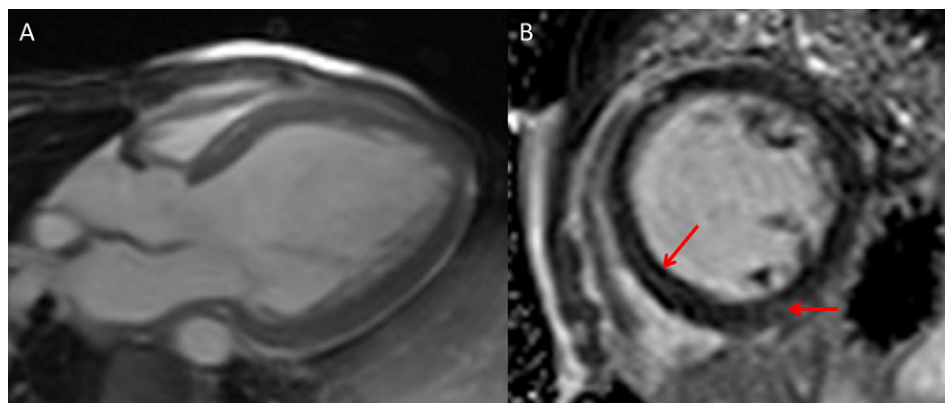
Cardiac magnetic resonance imaging. Panel A: parasternal long-axis view of the left ventricle showing its dilatation and global hypertrophy. Panel B: phase-sensitive infrared single-shot sequence showing linear and nodular intramyocardial enhancement (arrows), consistent with non-ischaemic pattern of myocardial fibrosis.
